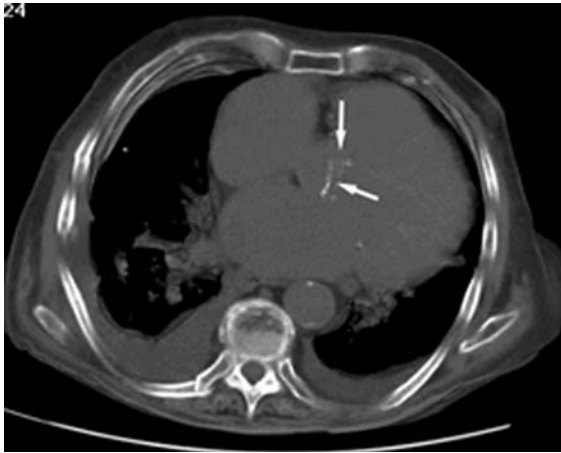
Non-contrast-enhanced multidetector CT examination from a 60 year old man with heart failure and a bicuspid valve aortic stenosis. Notice the faint calcification (arrows) along the commissural edges of the valve leaflets.
